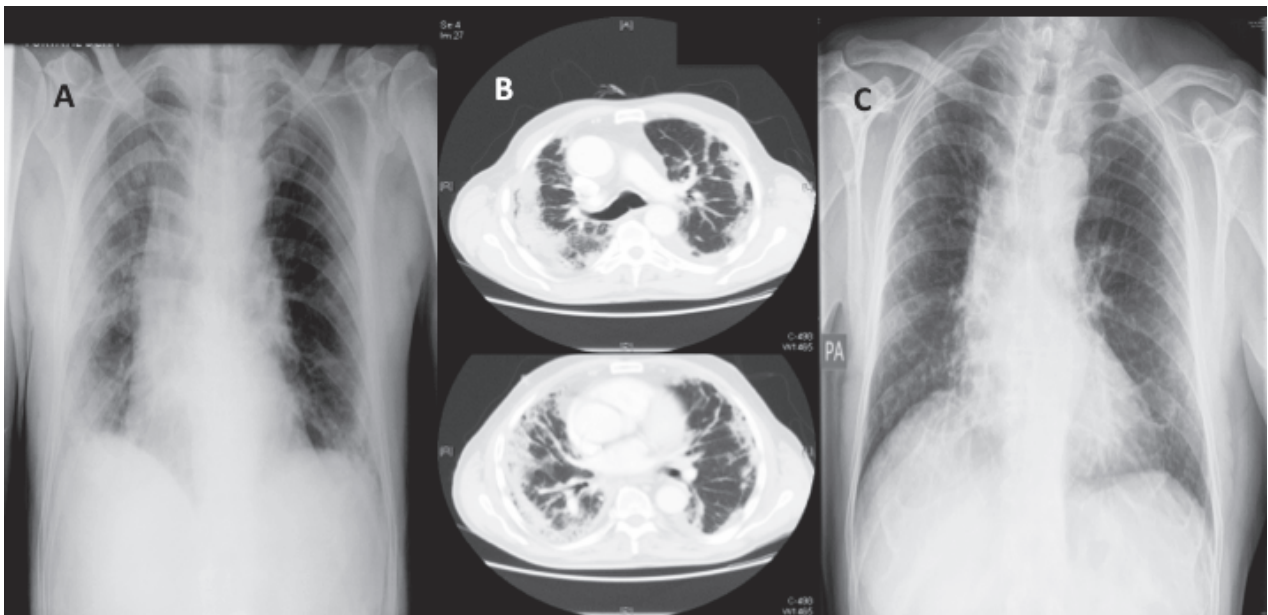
A: Chest X-Ray showing bilateral alveolointerstitial infiltrates. B: CT scan showing ill-defined ground-glass opacities and mild right pleural effusion. C: Chest X-Ray showing a complete resolution of the infiltrates
